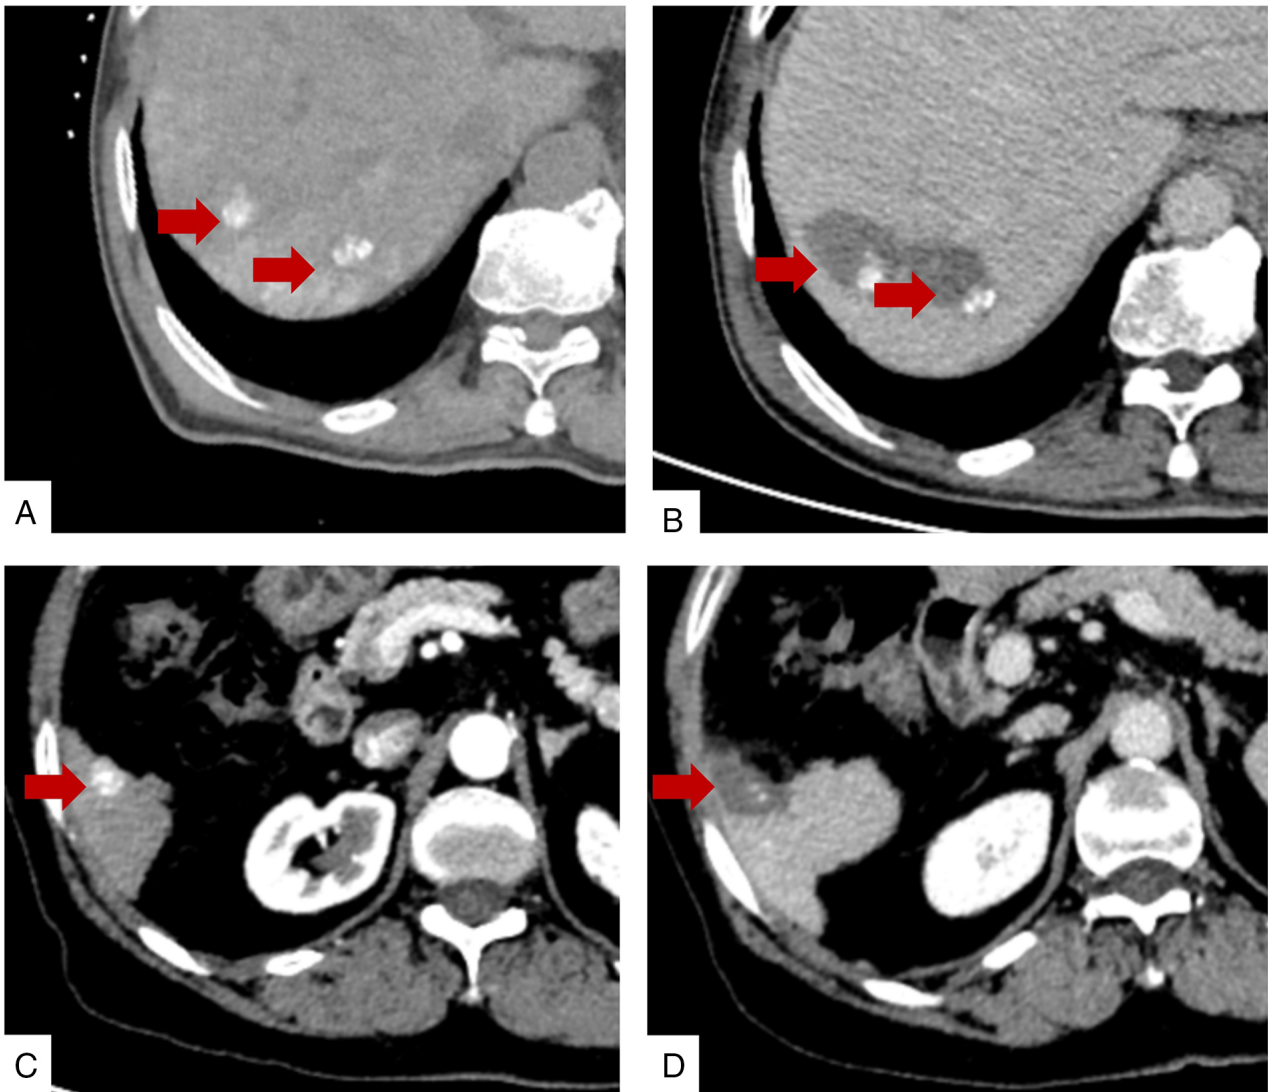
Comparison of imaging before and after combined treatment for patients. (A) CT scan of a 49-year-old male patient revealed tumor recurrence following transcatheter arterial embolization. (B) At 1 month after undergoing microwave ablation, a follow-up CT scan showed no enhancement in the tumor area. (C) A 69-year-old female patient, who had undergone liver resection, was found to have a right intrahepatic metastatic nodule measuring 1.1 cm in diameter on an enhanced CT scan 3 months post-surgery. (D) At 2 months after microwave ablation, a re-examination CT scan showed no enhancement in the tumor area.
